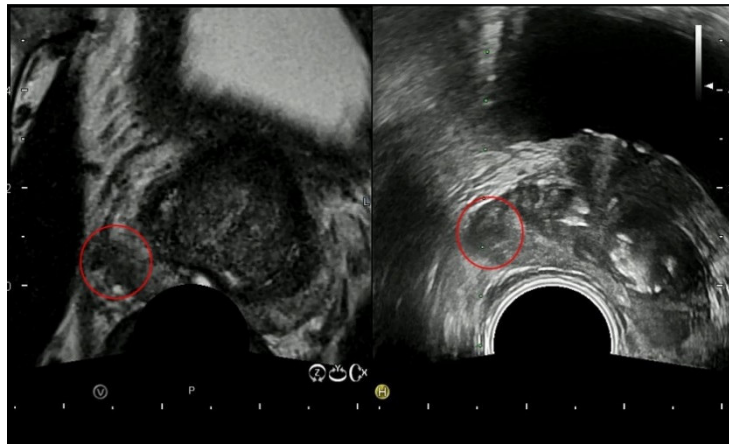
Example of a sensor based MRI/US fusion biopsy. According to anatomic landmarks the MRI and US images are fused. (Left) MpMRI shows a PI-RADS 4 lesion in the right peripheral dorsolateral zone. (Right) In the real-time US image targeted biopsies were obtained from the target lesion revealing a Gleason 3+4=7 PCa.
